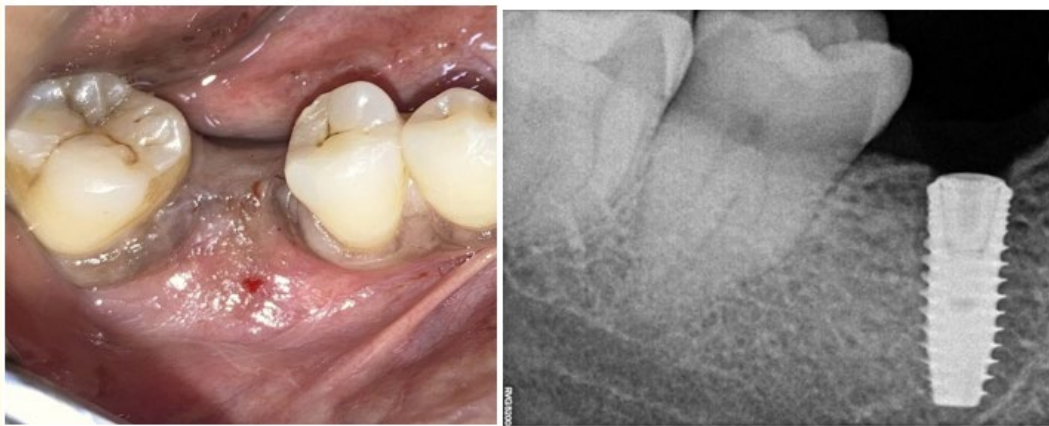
Clinical image and radiographic image of healing after 3 months of extraction of retained root 46, and placement of an immediate implant.
